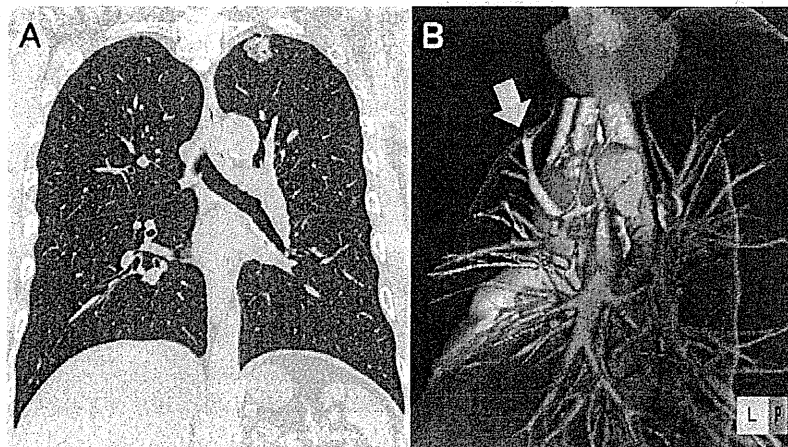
A 63-year-old male. (A) A partly solid lung cancer in the left S1 + 2 segments is seen on coronal CT; the maximal tumor diameter is 2.0 cm. (B) 3D-CTA with the virtual safety margin. The relevant intersegmental vein is V3b, between S1 + 2 and S3 (yellow arrow). Because the intersegmental vein is running outside of the virtual safety margin, S1 + 2 segmentectomy is able to be performed. (For interpretation of the references to color in this figure legend, the reader is referred to the web version of the article.)
